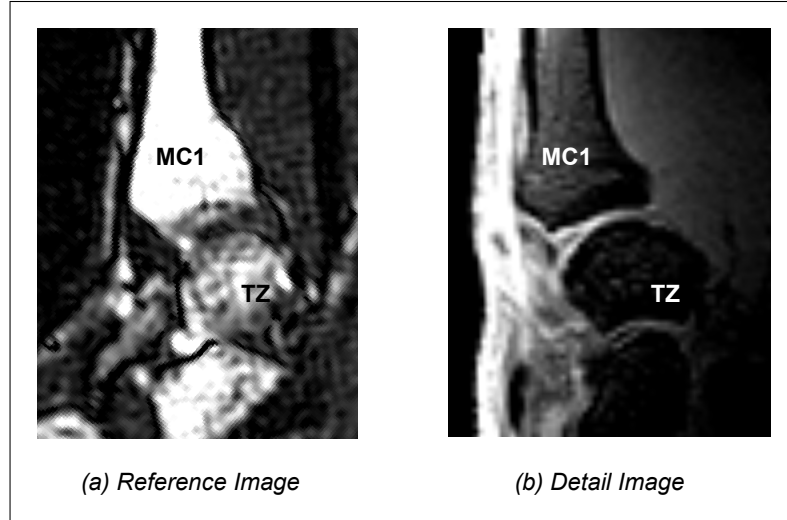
Comparison of an MRI slice of the CMC joint in the reference and the detailed image
